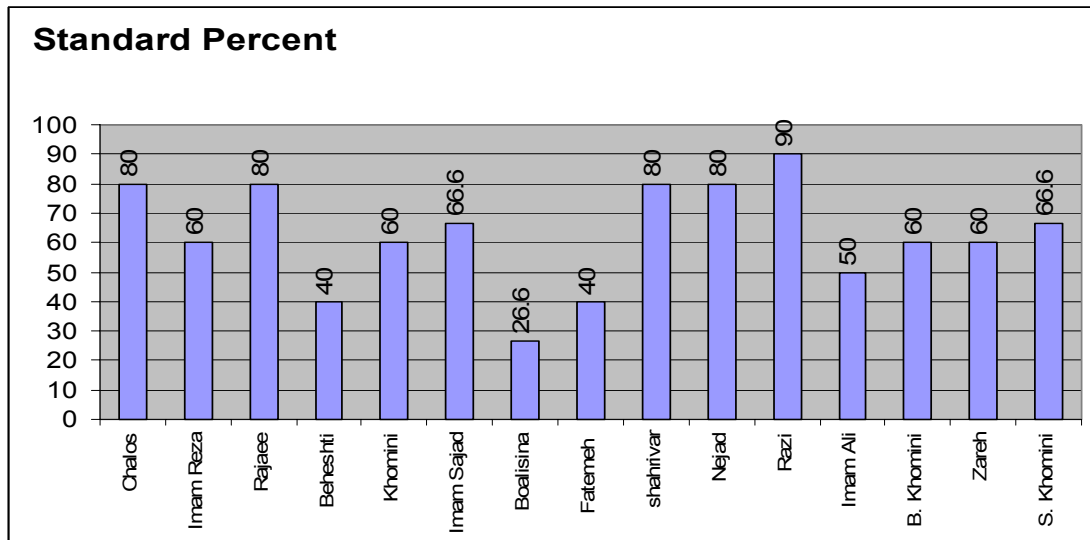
condition of control room at the radiography units considering the parameter under study.
